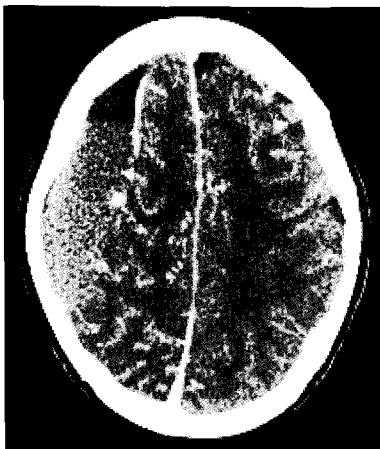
Preoperative enhanced computed tomography scan showing a right sided chronic subdural hematoma.
